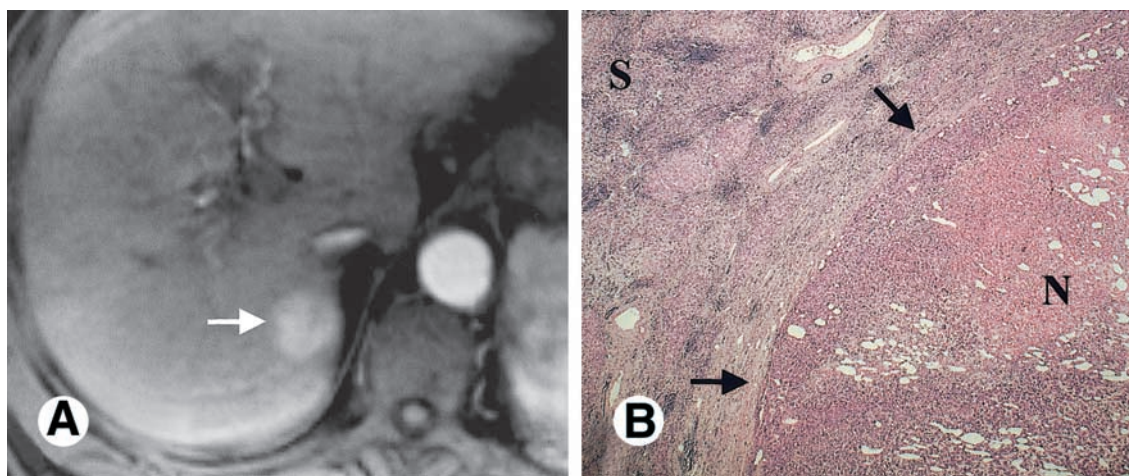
(A) A nodular lesion that enhances on the arterial phase of a contrast-enhanced MR image (arrow). The lesion was correctly diagnosed as an HCC. (B) The corresponding HCC in the cirrhotic explant liver (arrows) show areas of necrosis (N) and has a diameter of 2 cm. (Original magnification: [B] $\times 25$.)
